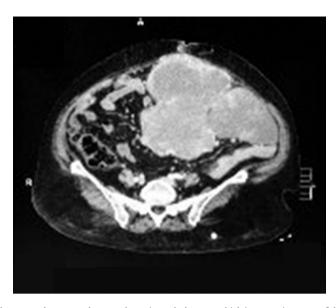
Axial computed tomography scan shows irregularly mass which is occupying most of the abdomen.
